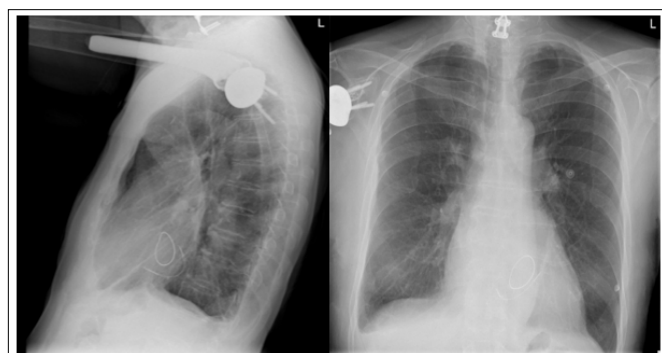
Chest X-Ray (AP and LL-view) Showing the Existing Carillon® Device and the surgically implanted Ring (Arrow)
